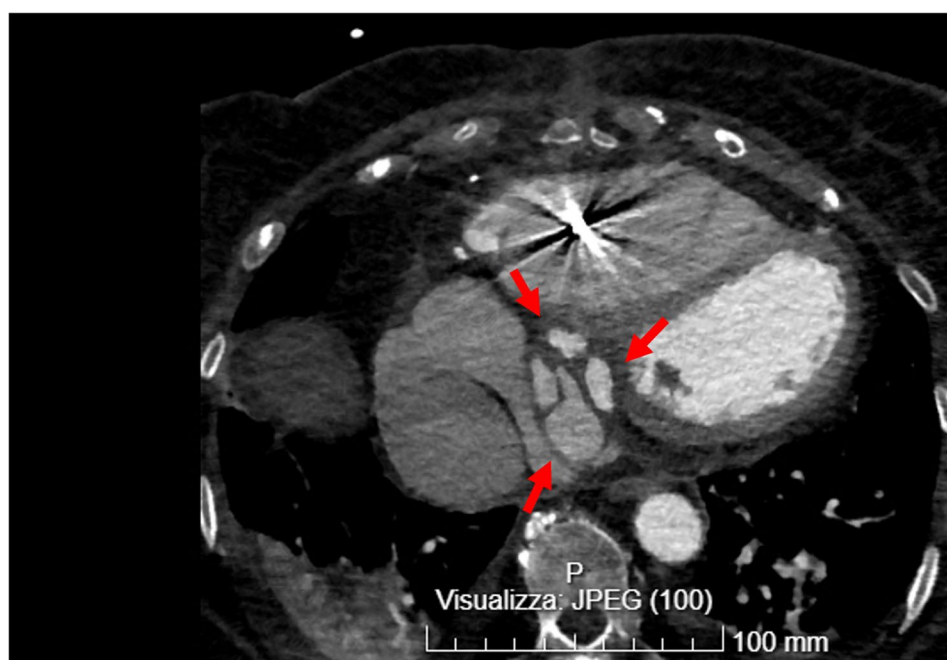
Computed Tomography image of a pluriconcamerated abscess (red arrows), pressing against the inferior vena cava. case 6
